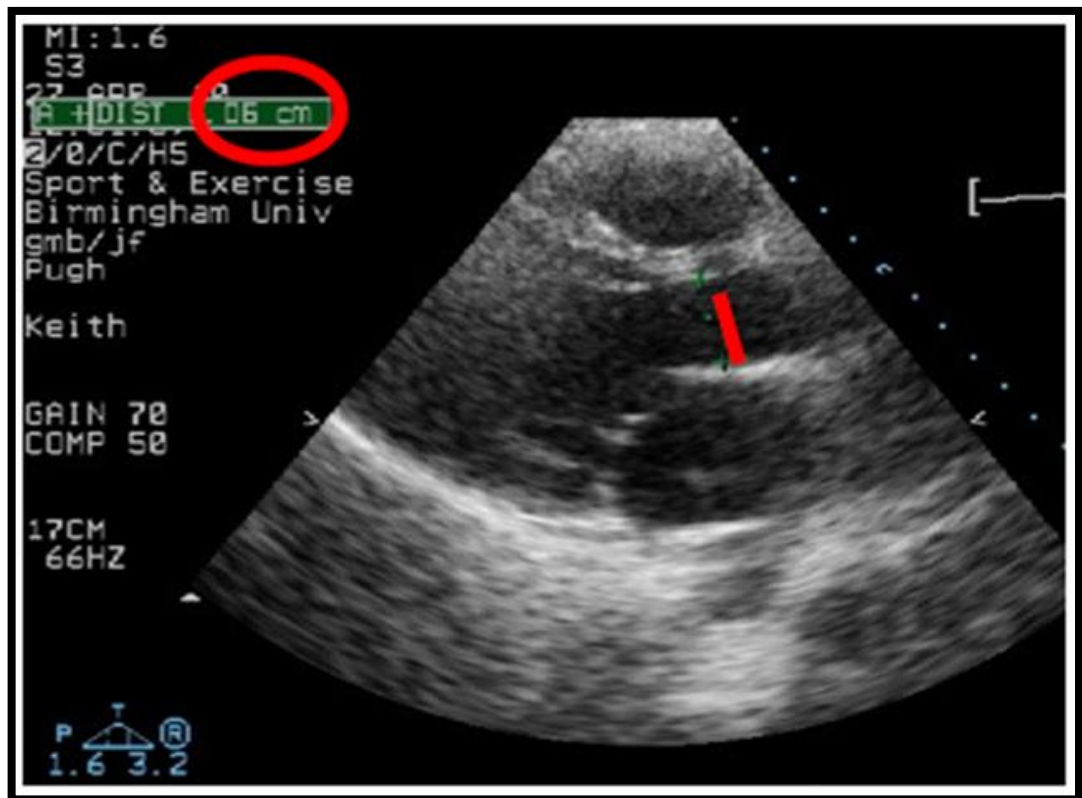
The aortic diameter from the parasternal view and the calculated area.
